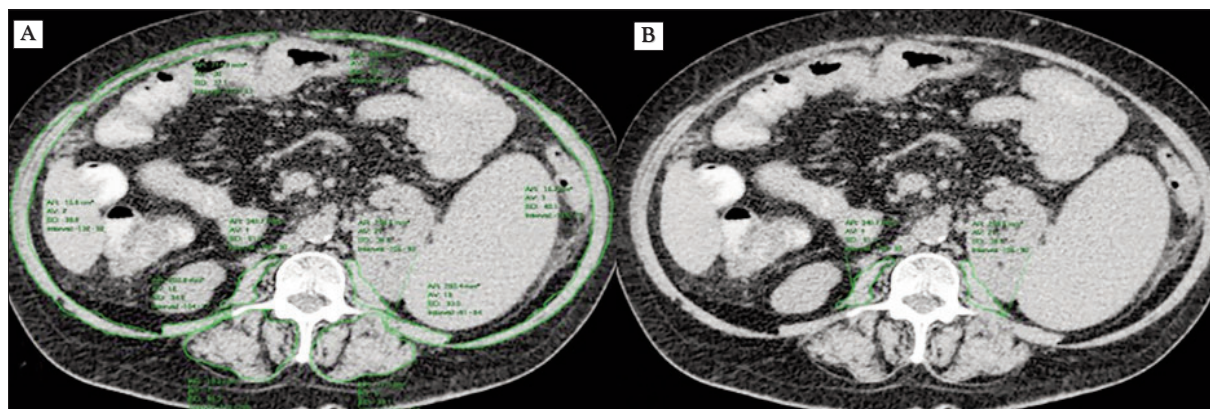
Native axial CT images showing SMI = 30 cm<sup>2</sup>/m<sup>2</sup> (A) and PMI = 2.35 cm<sup>2</sup>/m<sup>2</sup> (B).
